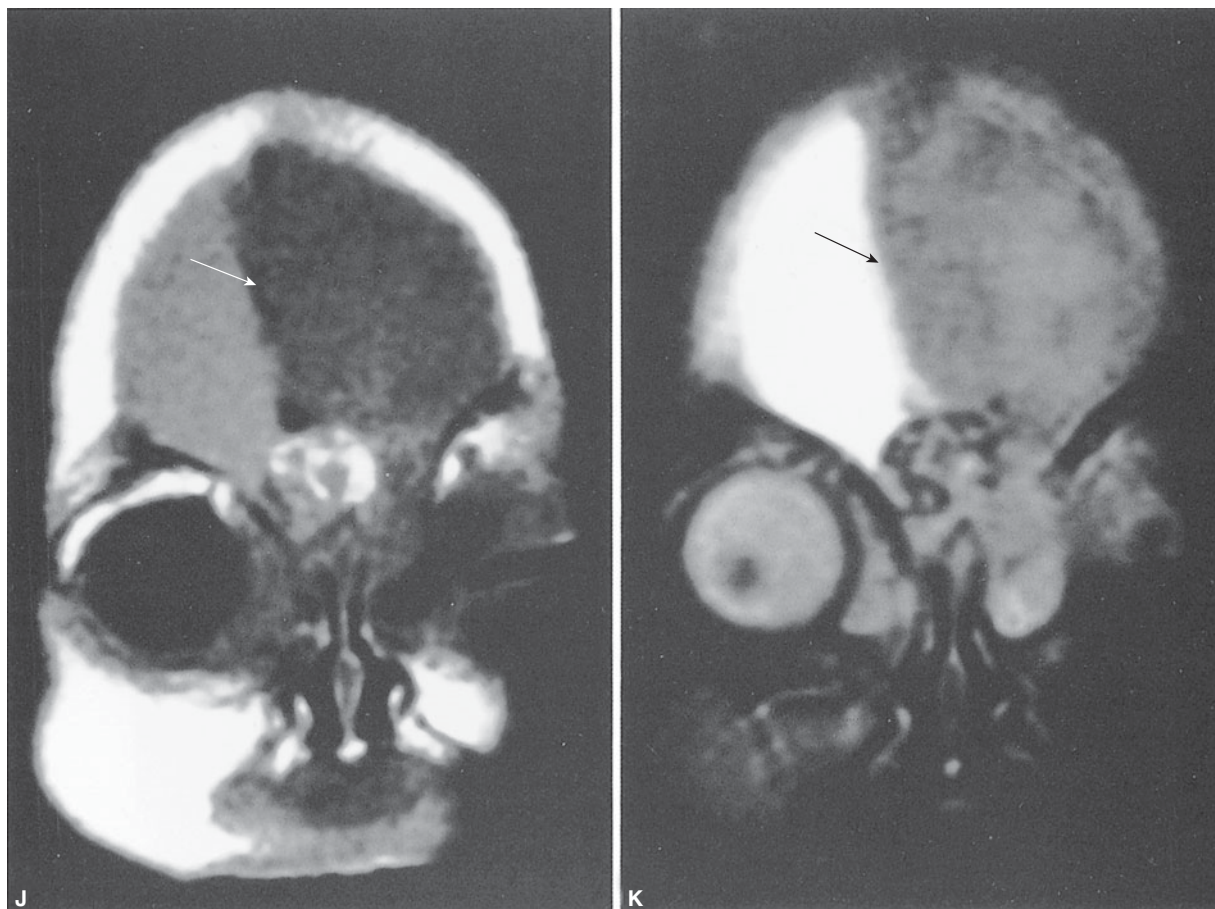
(continued) (J)–(M) Magnetic resonance imaging of the neonate. (J), (K) Coronal sections showing a large cystic area in addition to the encephalocele (arrow).
